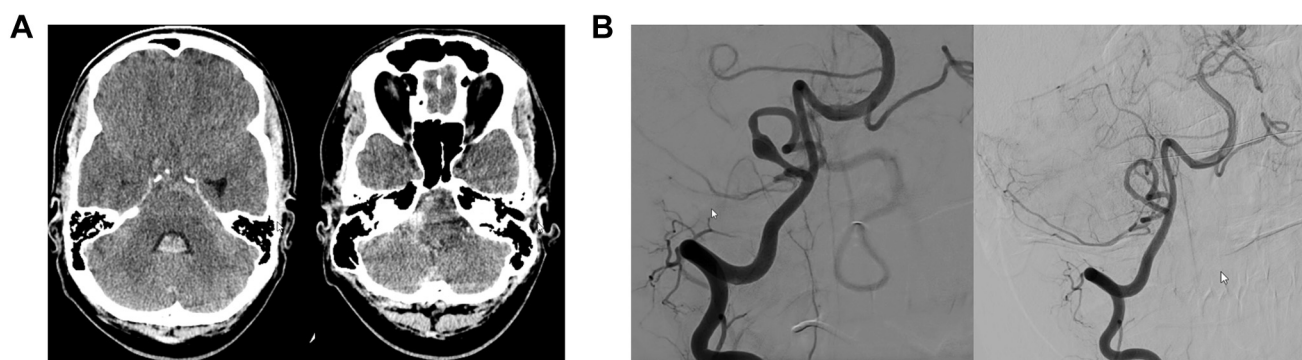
(A) A young patient with recent onset of cough presented with a severe headache and lethargy; computed tomography of the head showed subarachnoid hemorrhage and intraventricular hemorrhage. Patient tested positive for severe acute respiratory syndrome coronavirus 2 upon
